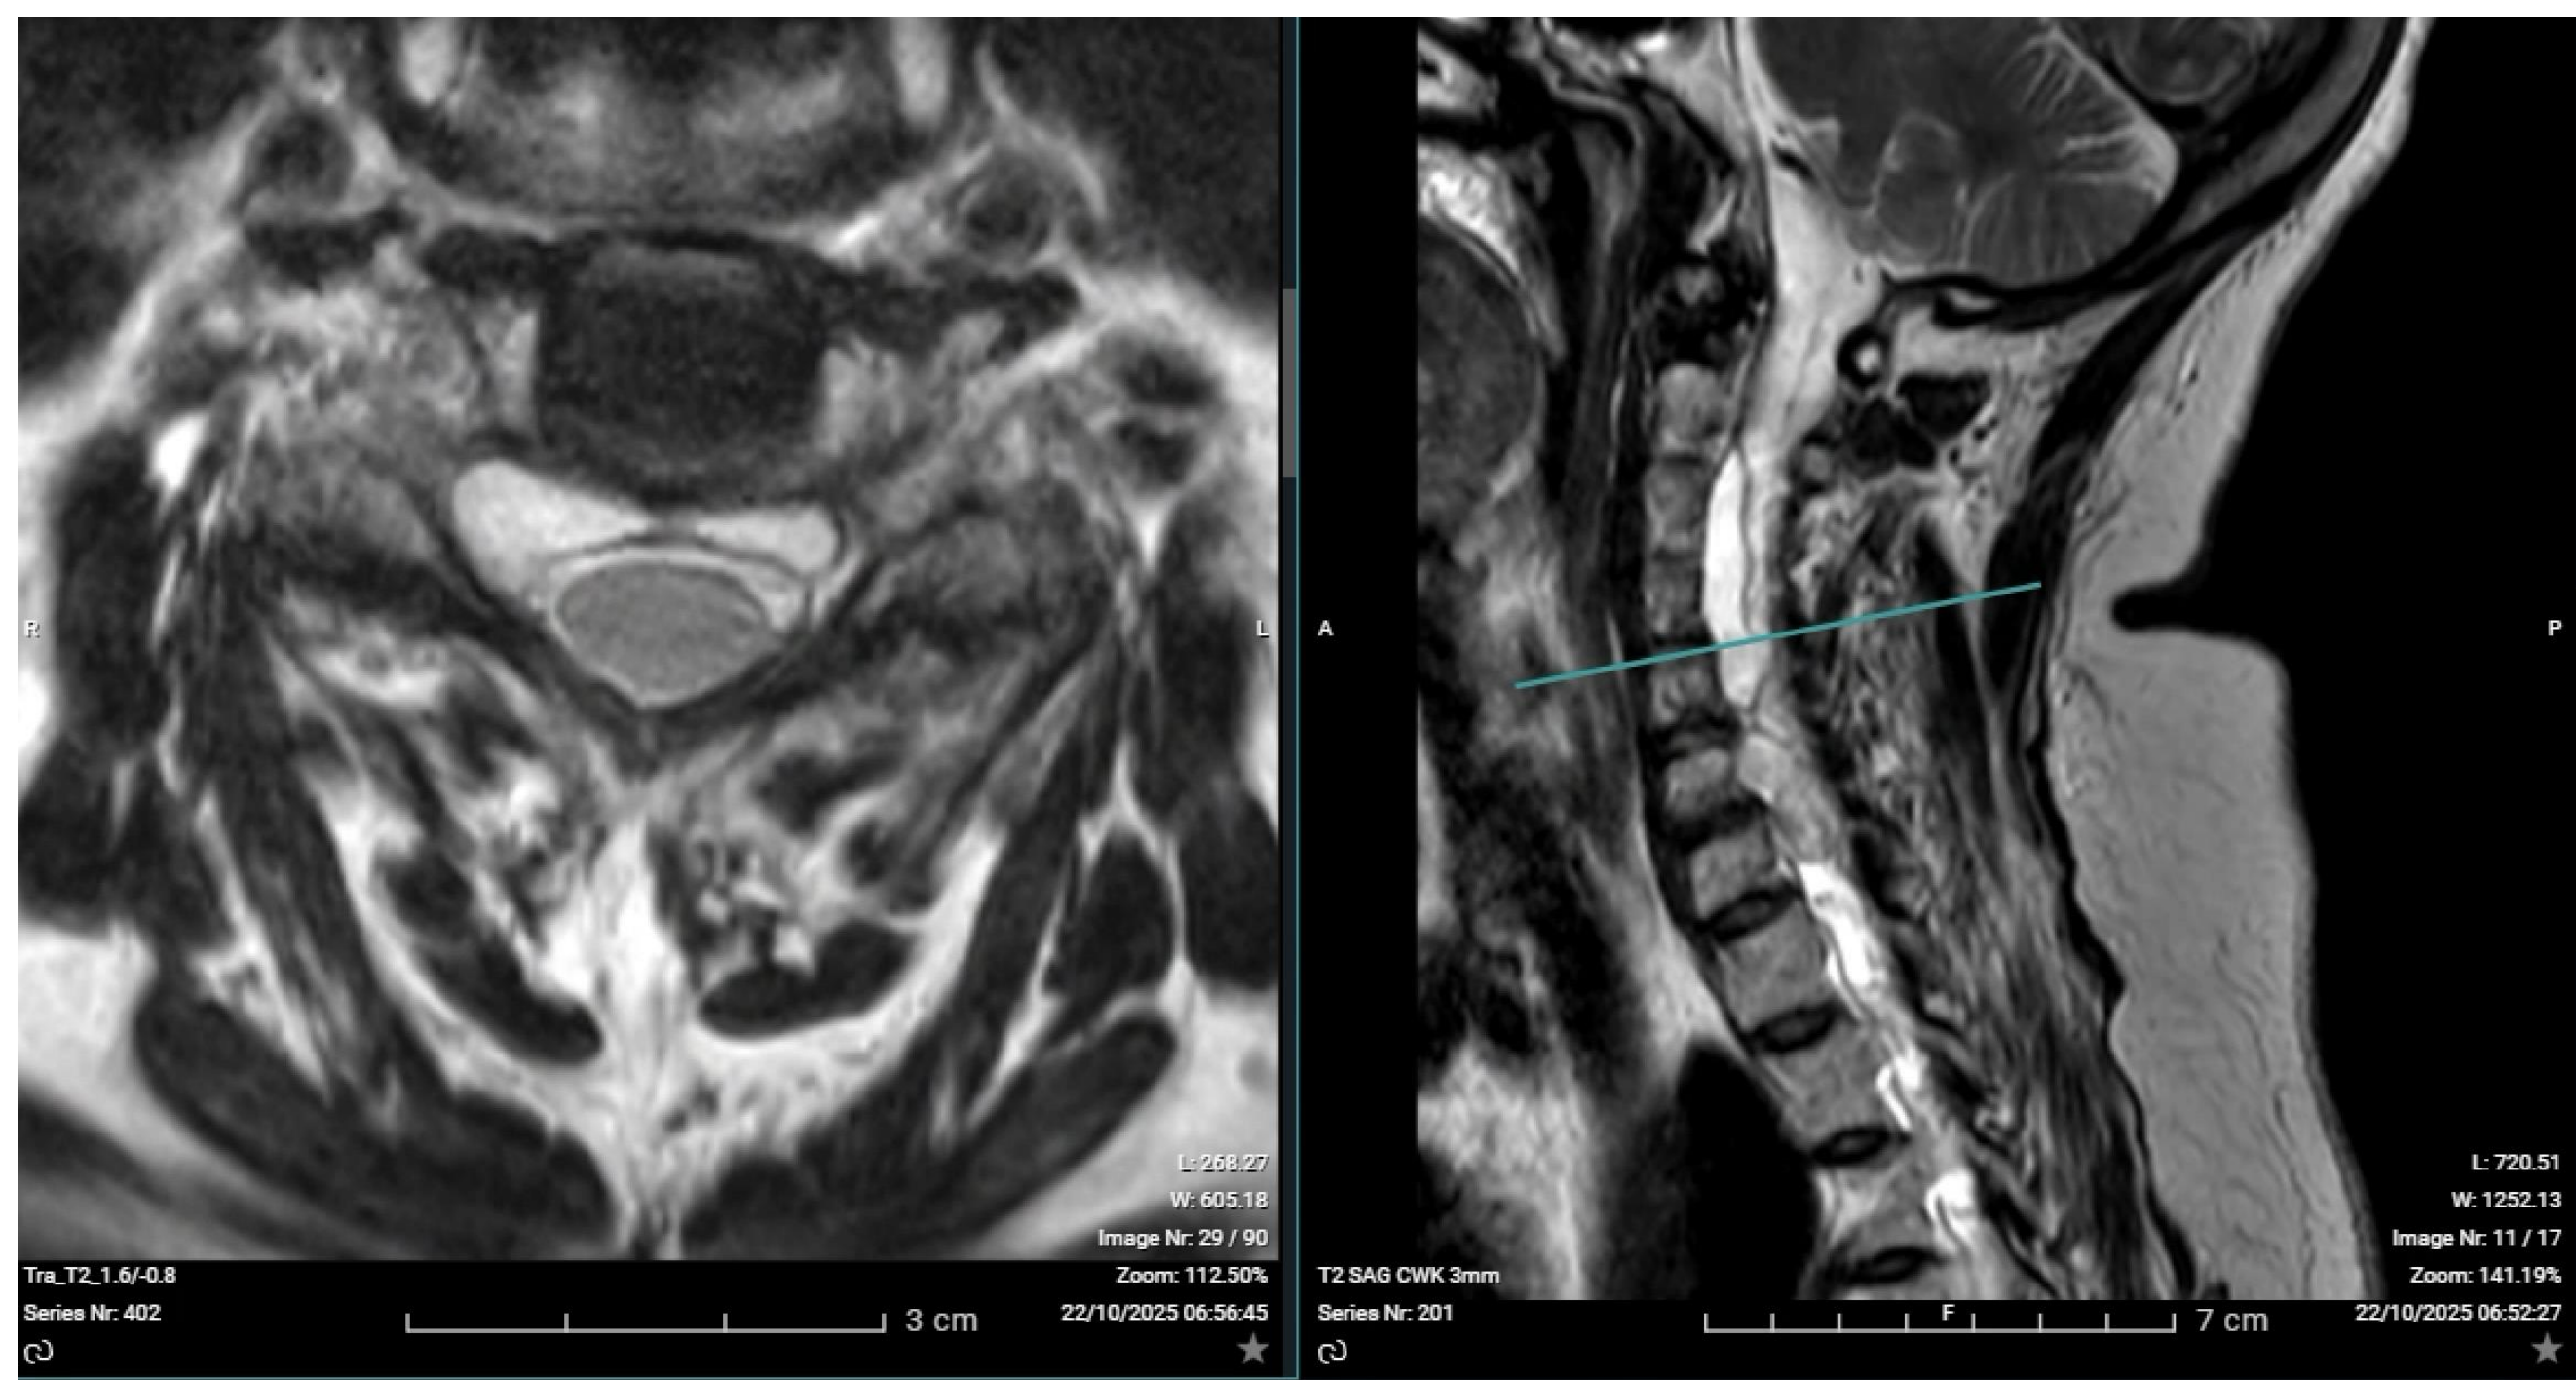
Cervical MRI showing an extensive epidural cystic lesion, consistent with an arachnoid cyst, extending from C2–C3 to C6–C7 with right-sided predominance
